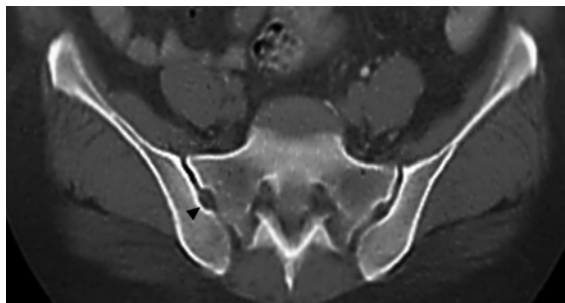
CT scan from a 50-year-old man shows semicircular defects (arrowhead) at the articular surfaces of the sacrum and ilium.
